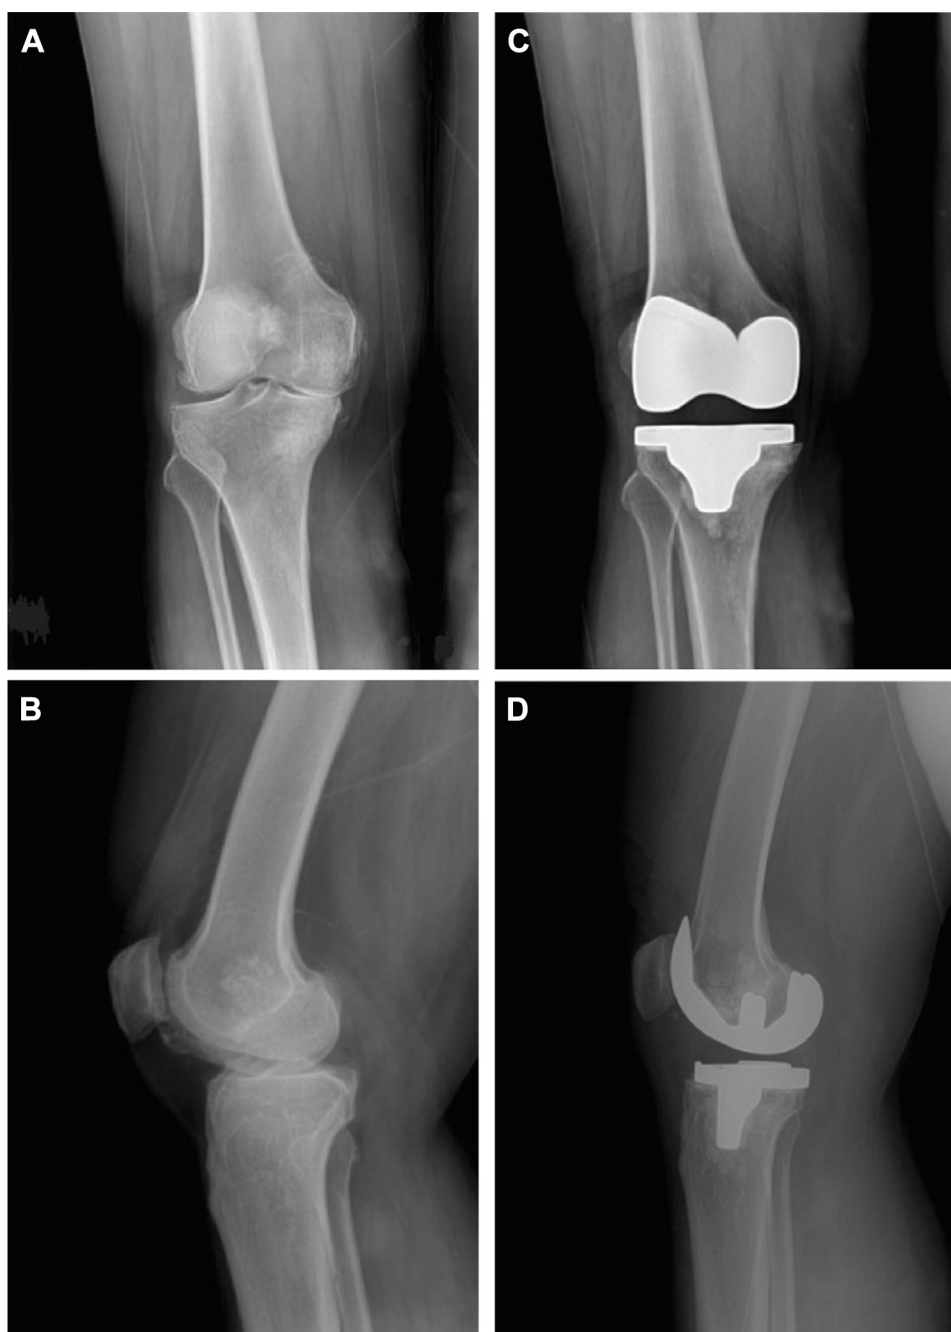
(A, B) Anteroposterior and lateral radiographs after subchondroplasty. (C, D) Anteroposterior and lateral radiographs of the same patient after total knee arthroplasty.
